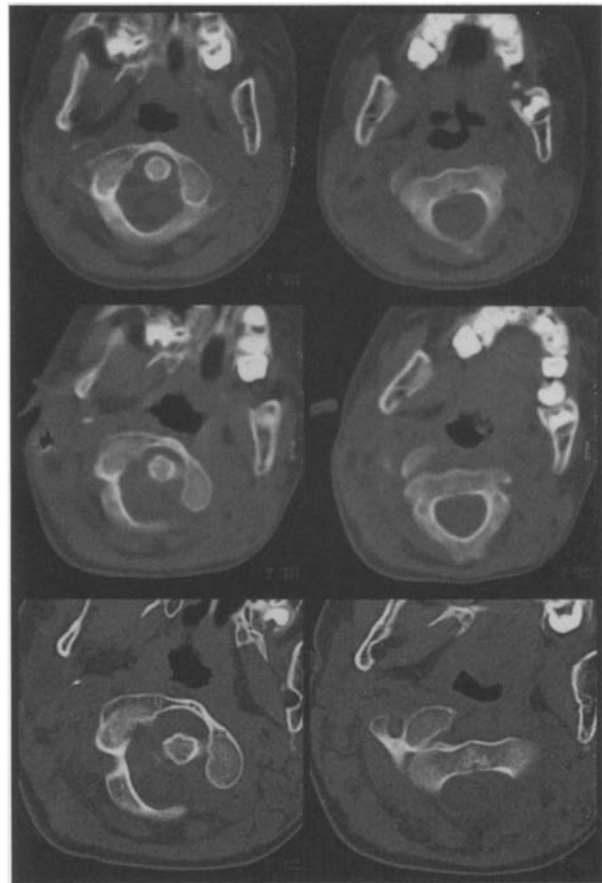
Sequential CT scans of the neck showing the development of atlanto-axial subluxation (AAS) over time. *Top* Eight days after admission. Bone windows show rotation within a normal range. The distance between the posterior border of the anterior ring of the atlas and the anterior aspect of the dens axis is 1.5 mm, representing a type I AAS. *Middle* Four weeks after admission. Further progression of rotational dislocation is present, but the dens is still in a normal position. The distance between the atlas and dens is 3 mm. Soft tissue window pictures at this point show no remaining edema or other inflammatory signs. *Bottom* Two months after admission. A type II AAS is seen. The atlas has rotated with the left lateral mass acting as the pivot, and the dislocated dens indicating overdistention of the transverse ligament. The distance between the atlas and dens is 7–8 mm. Subluxation has developed on the side contralateral to the resolved retropharyngeal abscess
